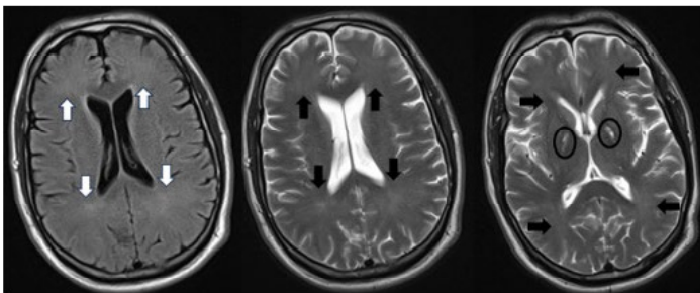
Magnetic resonance imaging at onset of neuropsychiatric decline (19 days after initial visit) showing symmetric subtle hyperintensity in frontal and parietal lobes (axial FLAIR sequence on far left with white arrows, axial T2 sequence in middle and far right with black arrows) and hyperintensity of the bilateral globi pallidi (ovals) with normal-appearing gray matter.
